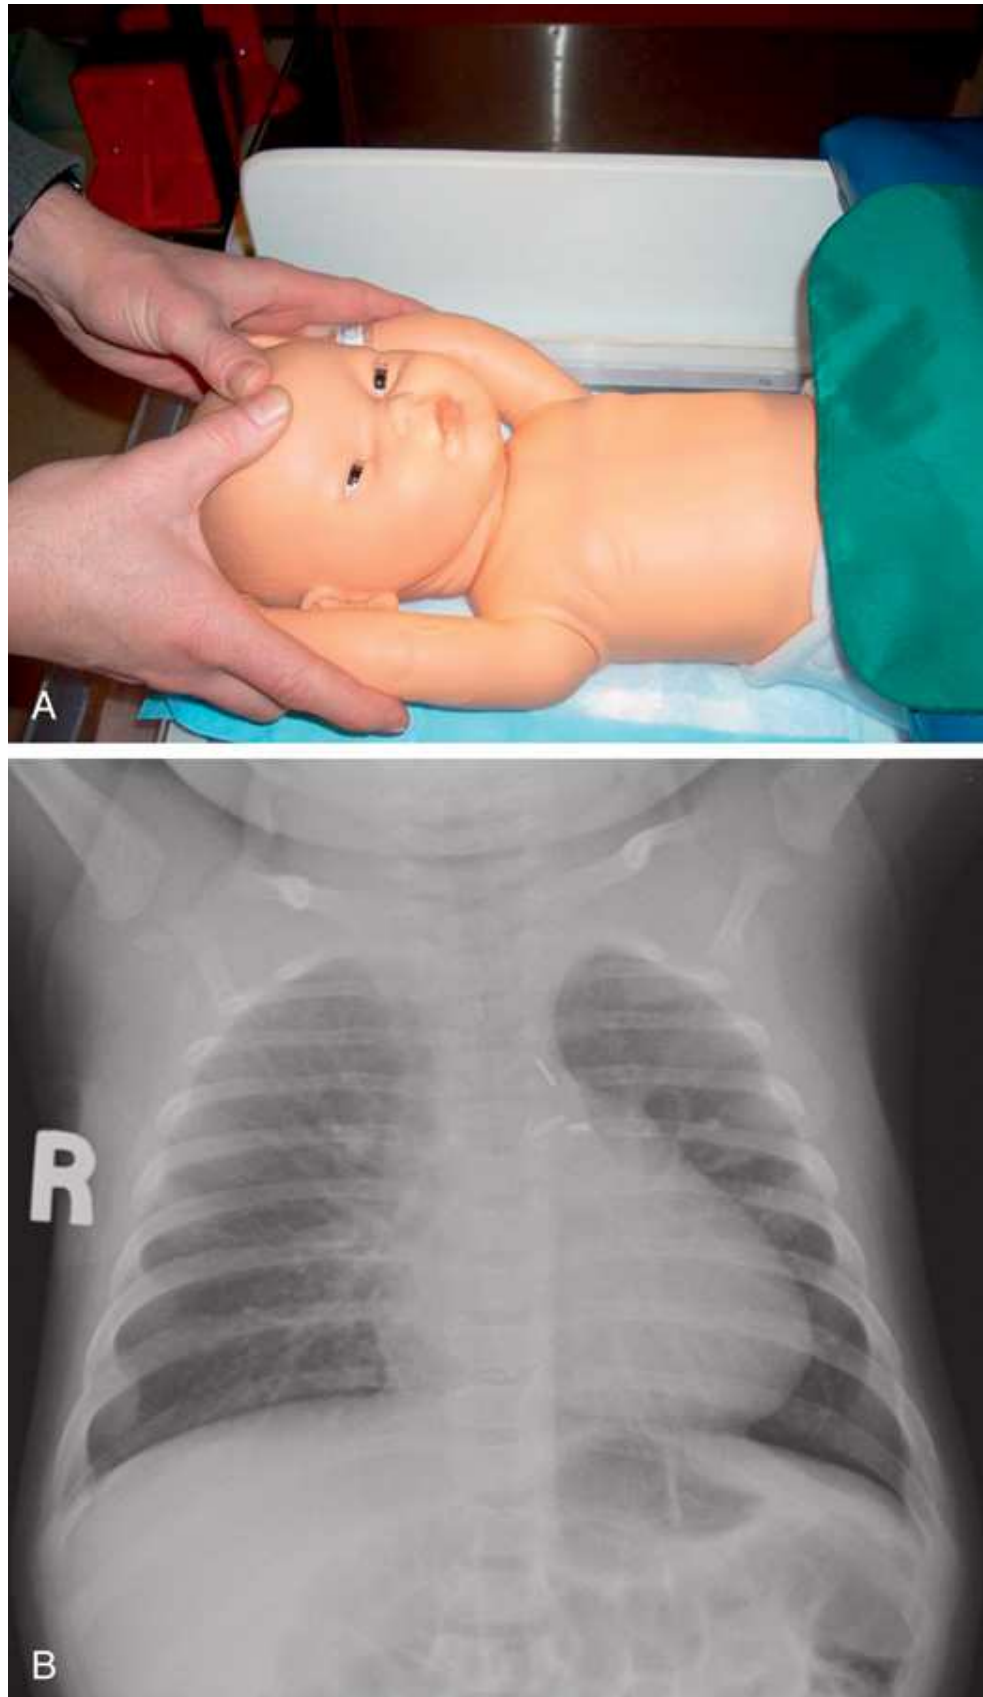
(A) Supine AP chest x-ray for an infant younger than 12 months. Parent immobilizes at the elbows with thumbs at or on sides of forehead. (B) AP chest image of infant younger than 12 months.
